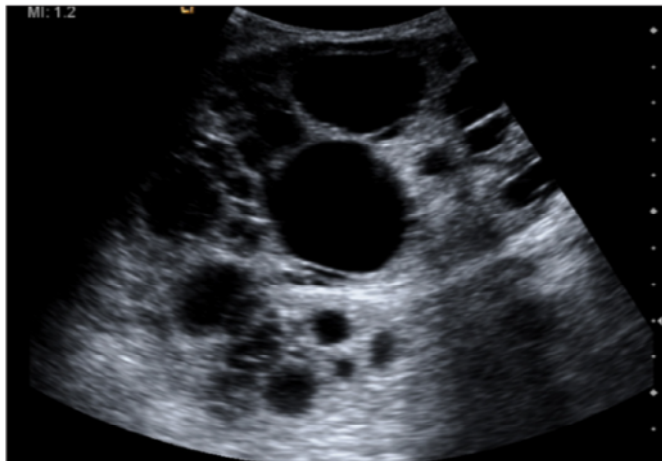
Ultrasound image from Case 1 showing multiple cortical cysts replacing the entire renal parenchyma of the transplant kidney.
